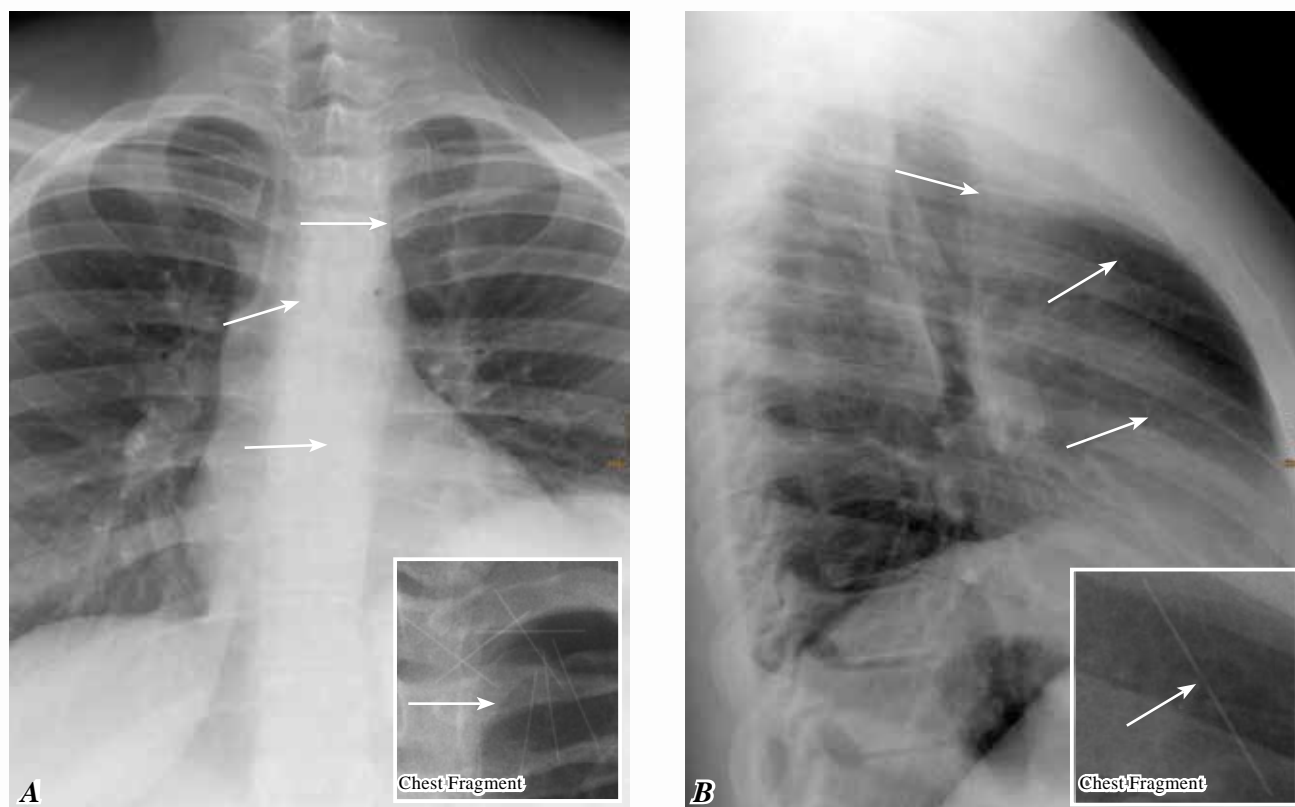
Chest (A) and lateral chest (B) x-ray p.a. one month prior to presentation at our emergency department showed multiple needles projected on the superior and anterior mediastinum (white arrows)
